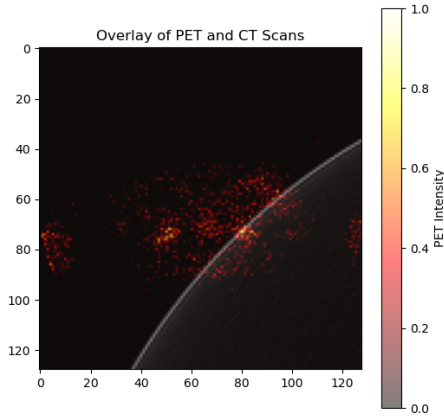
PET and CT scans overlaid
